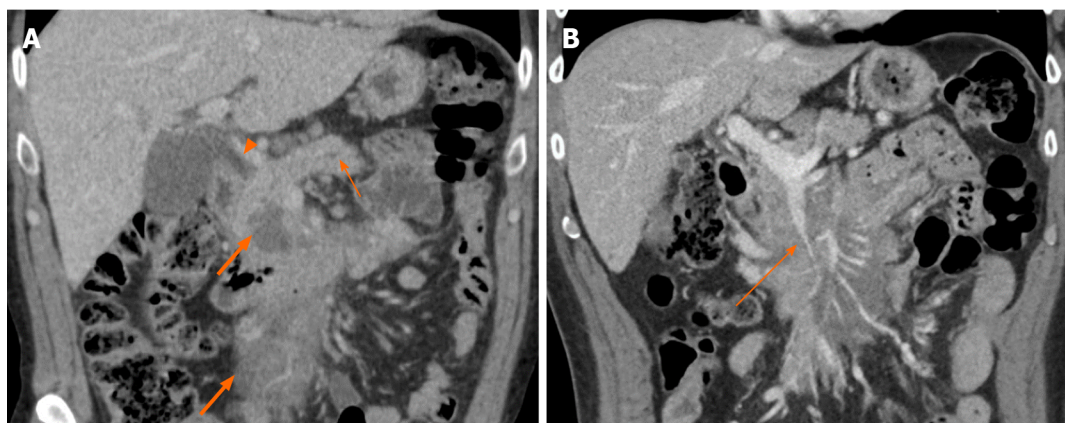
A 72-year-old male presenting with abdominal pain and jaundice. Coronal computed tomography imaging shows hypoenhancing homogenous infiltrative mass (thick arrows, A) infiltrating the mesenteric root. A: There is pancreatic duct dilation (short thin arrow) and common bile duct obstruction (arrowhead); B: There is stenosis of the superior mesenteric vein (long thin arrow) caused by the tumor.
